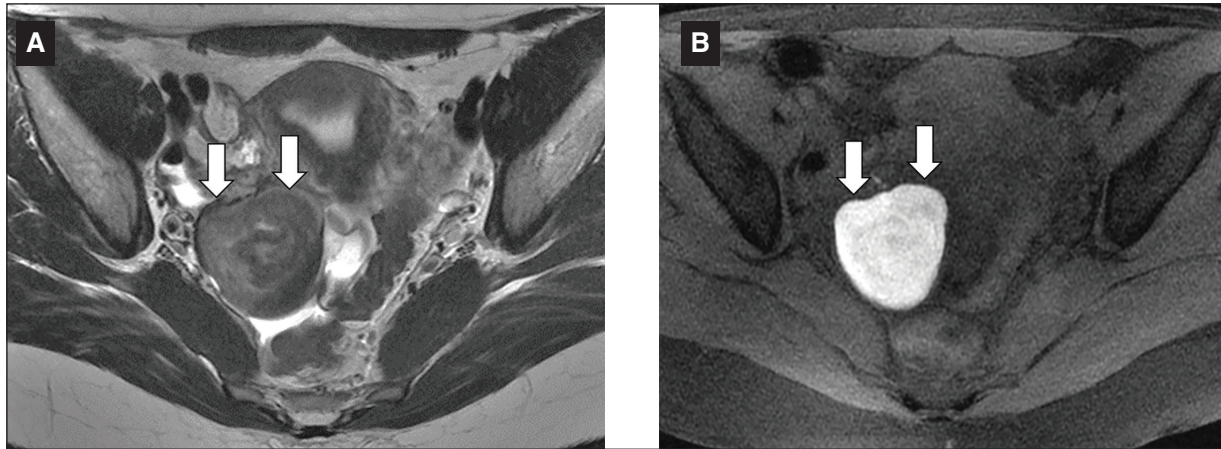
Endometrioma in a 29-year-old infertile woman. A: axial T2-weighted MRI demonstrating a cyst (arrows) with the shading sign representing old hemorrhagic content. B: axial T1-weighted fat-saturated MRI demonstrates hyperintense signal intensity (light bulb bright sign) characteristic of endometriomas (arrows).
